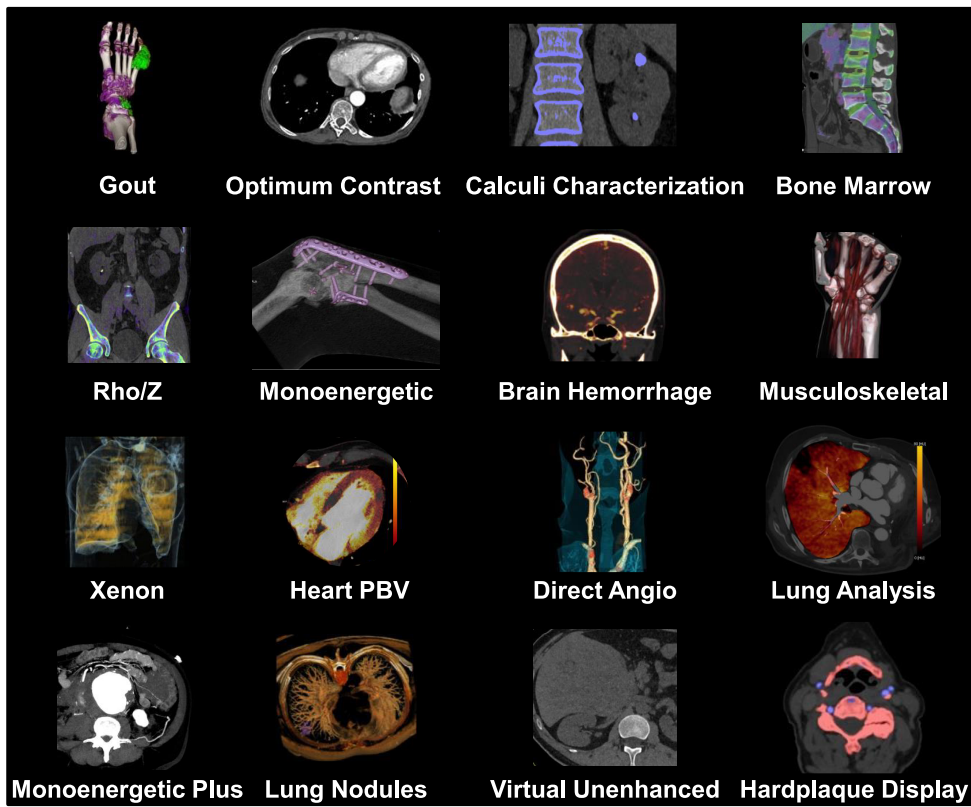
Syngo.CT Dual Energy application examples. Virtual unenhanced contains liver VNC, lung analysis contains lung PBV. Courtesy of Siemens Healthineers, Forchheim, Germany.
